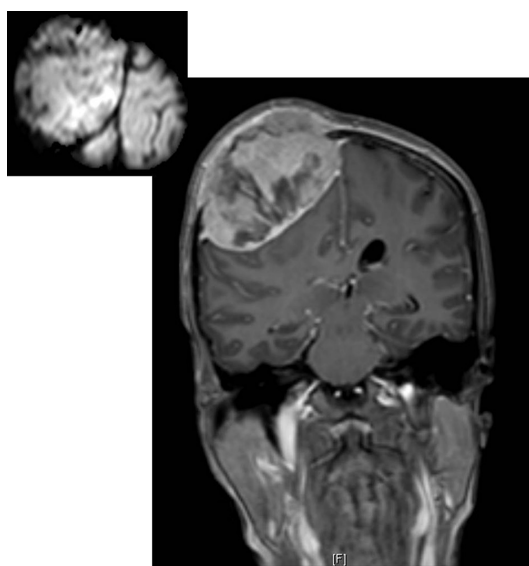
T1-weighted MRI with contrast showing a lobulated expansile, intensely heterogeneously enhancing lesion arising from the right frontoparietal region (size 77×52×88 cm).
